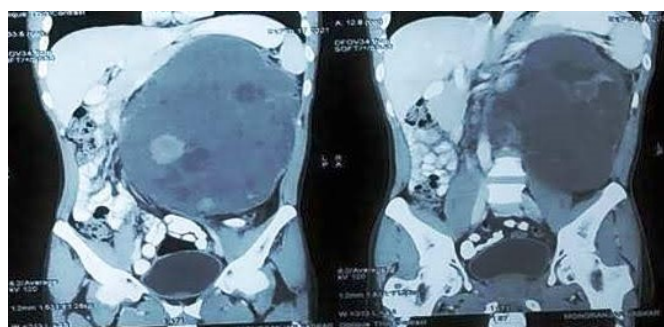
Contrast-enhanced computed tomography demonstrated a heterogeneous, moderately enhancing mixed solid–cystic mass arising from the lower pole of the left kidney
